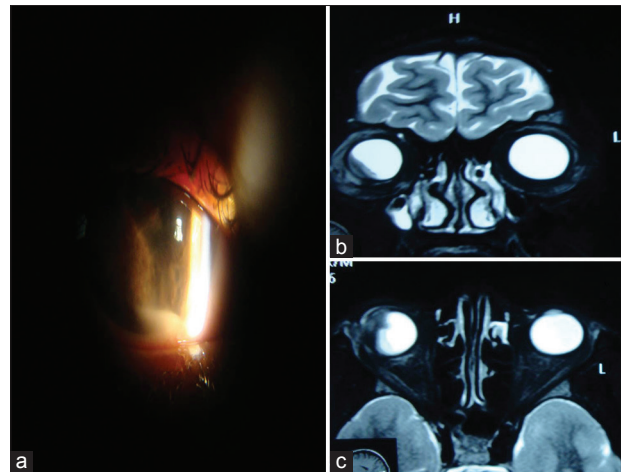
(a) Slit-lamp photograph of anterior chamber of right eye showing hypopyon with anterior chamber reaction (flare +++, cells +++); (b and c) the lesion in the ciliary body region of right eye in T2-weighted image of magnetic resonance imaging in coronal and axial planes, respectively. Imaging gave the probable diagnosis of ciliary body melanoma
